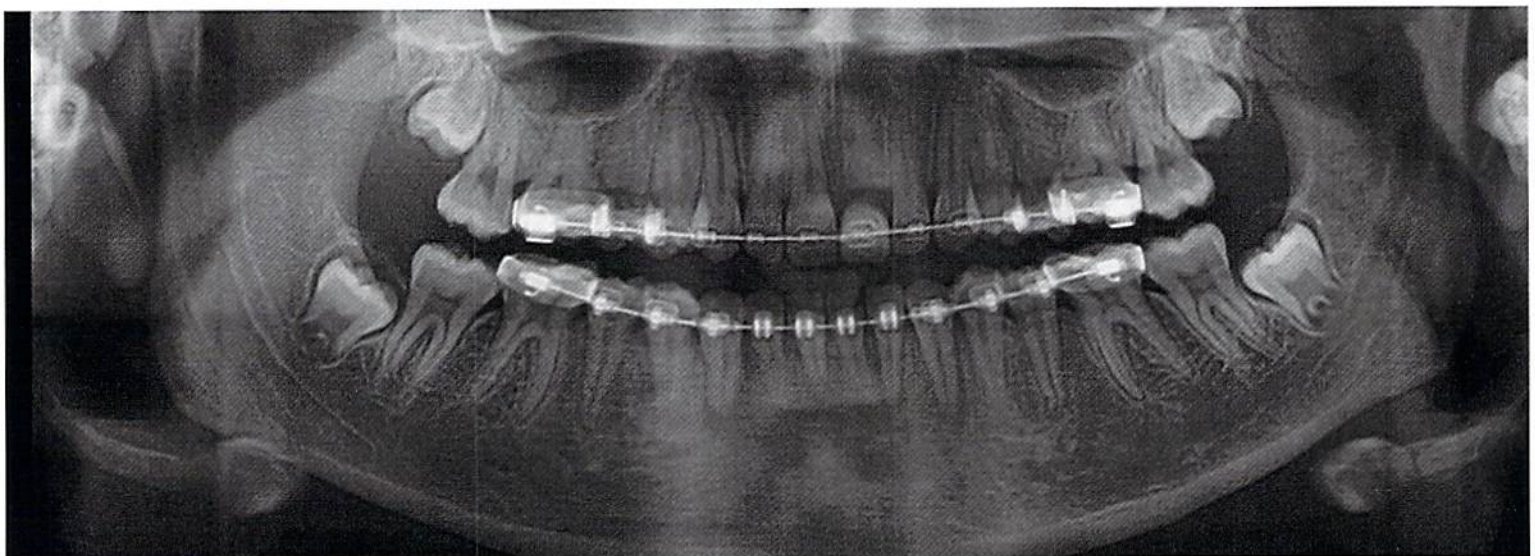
Panoramic radiograph after 23 months of orthodontic treatment. Note maintenance of vertical bone level
